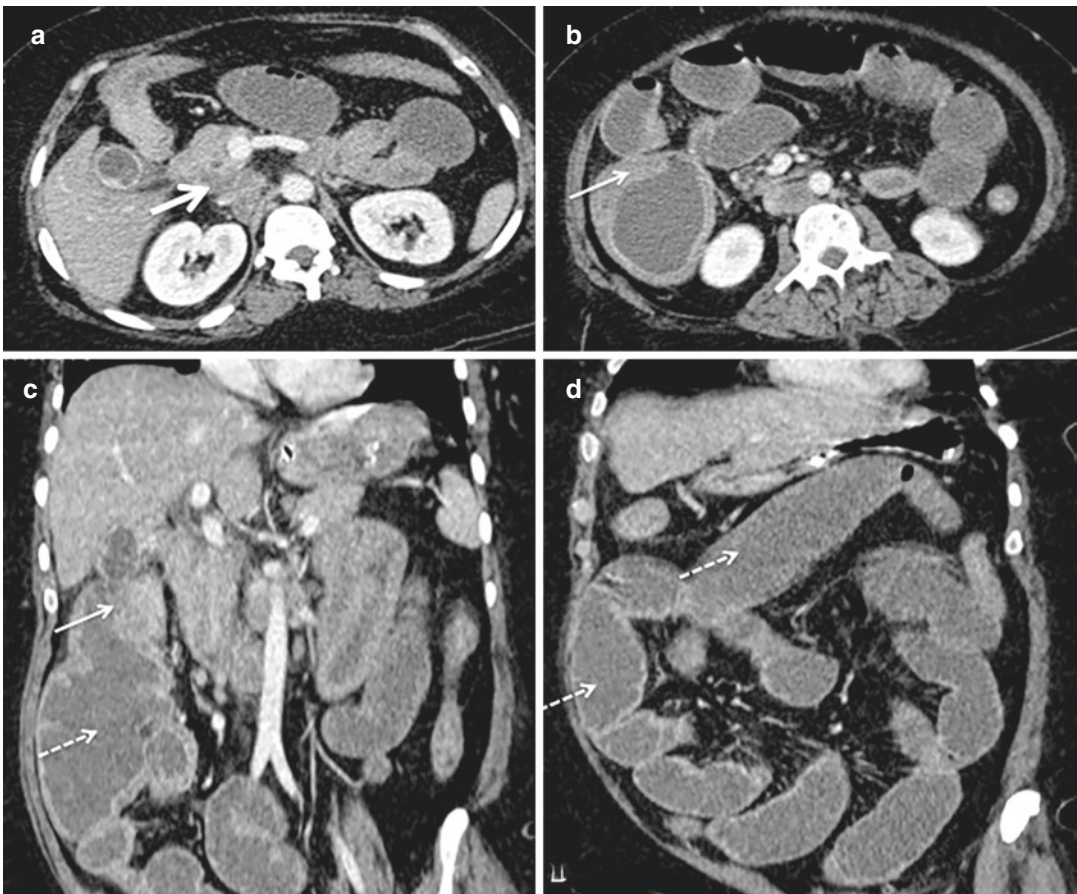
42-year-old man who presented with clinical features of intestinal obstruction. (a) Axial contrast-enhanced CT image shows enlarged necrotic peripancreatic lymph nodes (thick solid arrow). (b) Axial and (c) coronal contrast-enhanced CT images show asymmetrical circumferential wall thickening of the colonic hepatic flexure (thin
